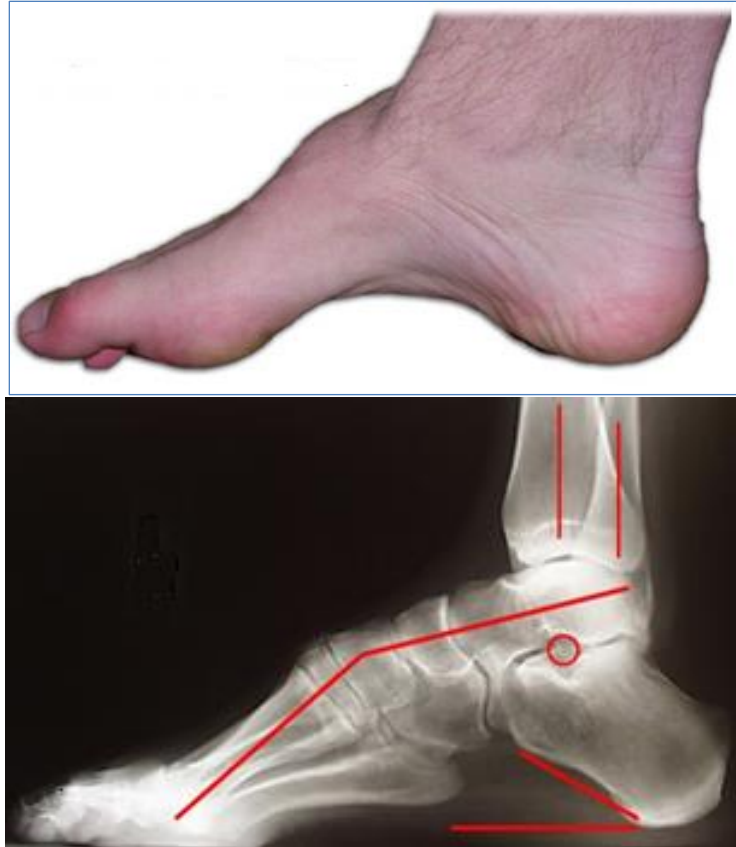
Charcot foot, normal and x-ray view of bony malformation
